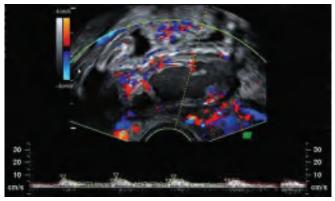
Transvaginal color Doppler of the same patient. Note prominent vascularization of thickened tubal walls
